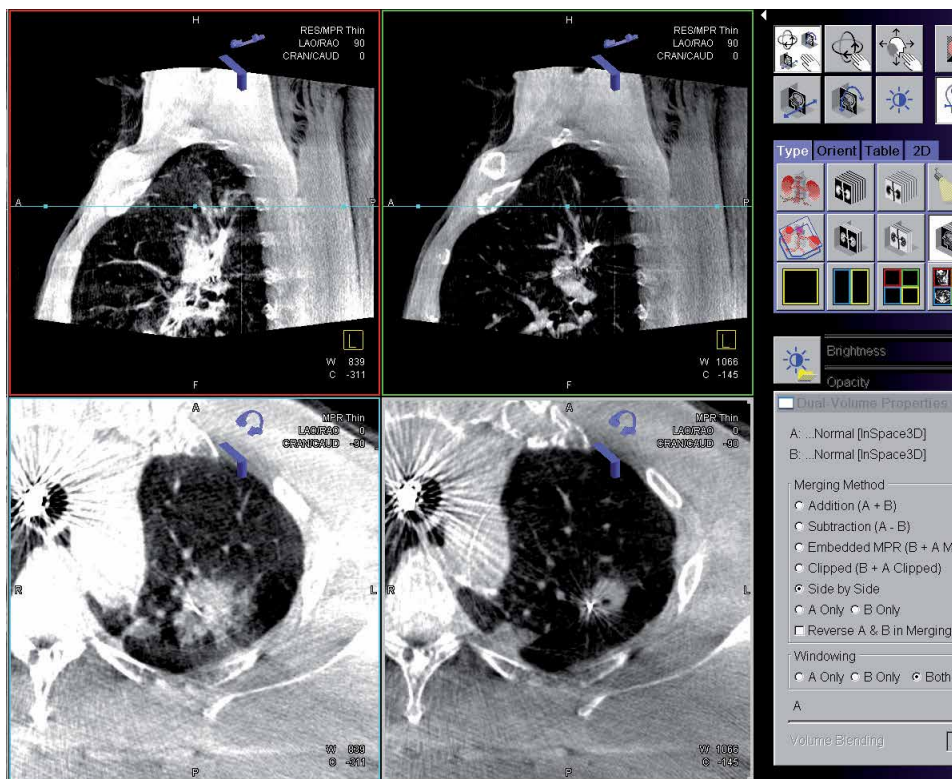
Cone-beam CT images showing left upper lobe adenocarcinoma bronchoscopically ablated by microwave energy. The right images show the Emprint™ catheter within the tumor before ablation while the left images show CT performed 10 min post ablation.
